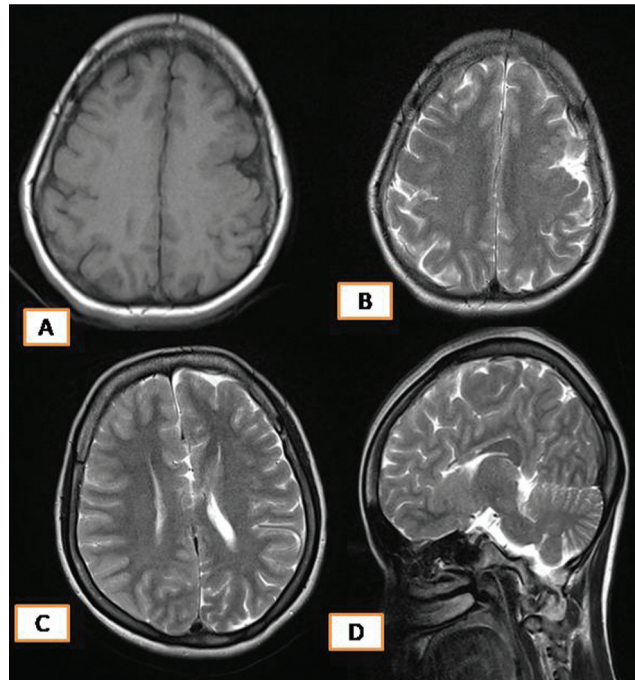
(A, B) Magnetic resonance imaging (MRI) brain axial T1- and T2-weighted imaging (T1WI and T2WI): focal abnormal cortical thickening with blurring of gray white matter junction noted in left posterior frontal lobe suggestive of malformation of cortical development. (C, D) MRI brain axial T2WI and sagittal T2WI: partial agenesis of corpus callosum is seen with nonvisualization of rostrum, genu, and anterior body with absent septum pellucidum.
